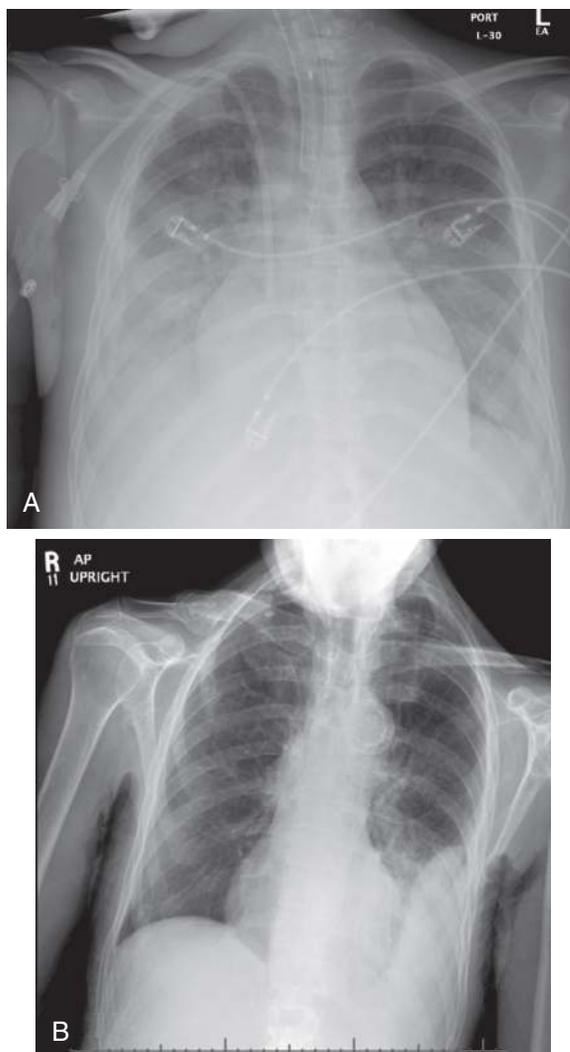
A, Semi-recumbent portable chest x-ray demonstrates bilateral basilar hazy opacities silhouetting the diaphragm. Large bilateral pleural effusions were confirmed on bedside ultrasound. B, Loculated effusion with “D-sign.”
